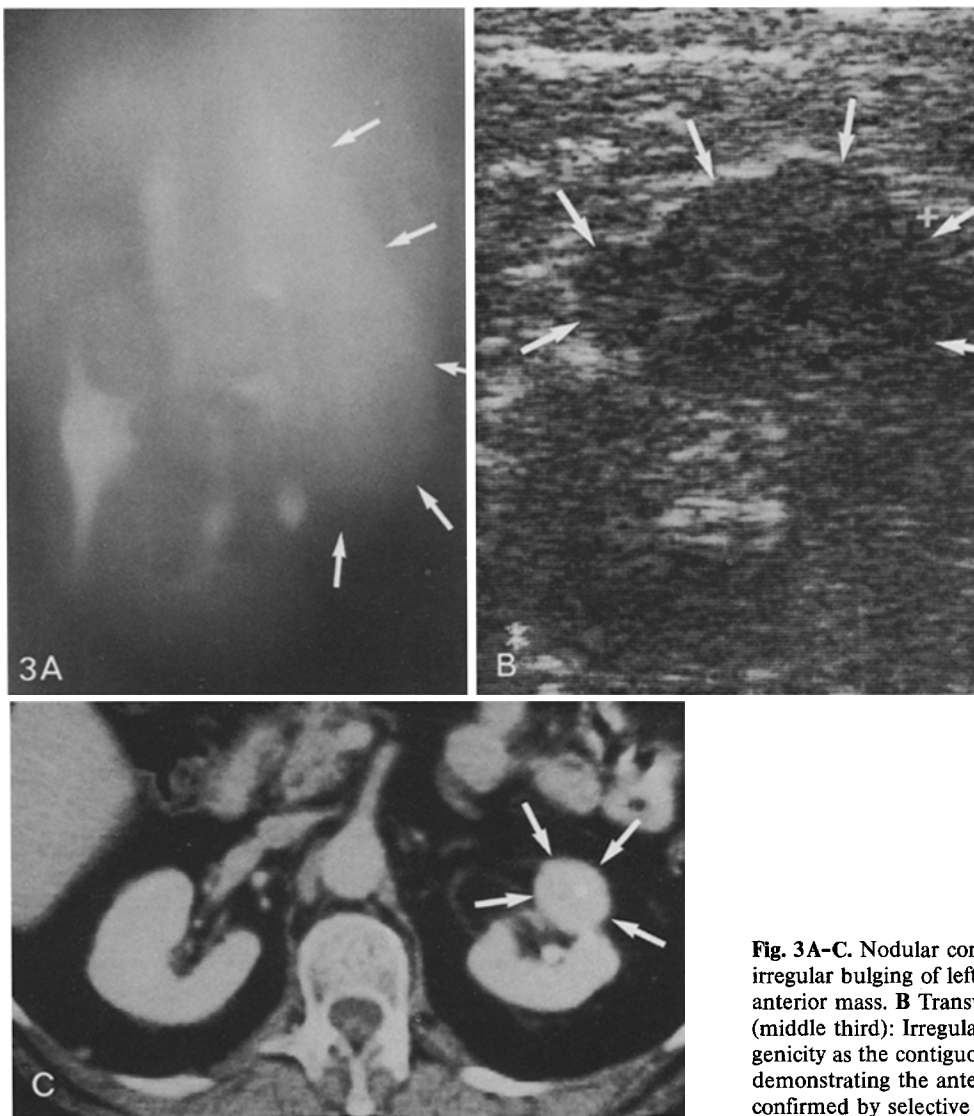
Nodular compensatory hypertrophy. A IVP reveals irregular bulging of left renal outlines (*arrows*) and a possible anterior mass. B Transverse sonogram of the left kidney (middle third): Irregular outlined anterior mass, same echogenicity as the contiguous cortex. C Contrast enhanced CT-scan demonstrating the anterior isodense pseudomass. Benignity confirmed by selective angiography
